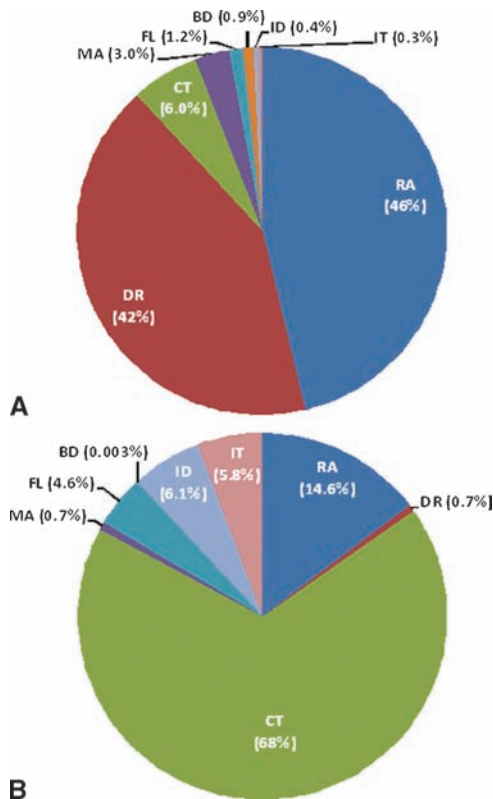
Distribution of the total annual number of examinations (A) and the total annual collective dose (B) over the various radiological modalities: radiography (RA), conventional fluoroscopy (FL), diagnostic interventional radiology (ID), therapeutic interventional radiology (IT), computed tomography (CT), dental radiology (DR), mammography (MA), bone densitometry (BD).
